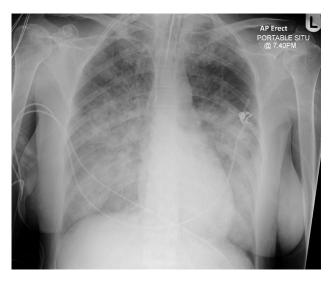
Chest roentgenogram on admission showing gross pulmonary edema.
